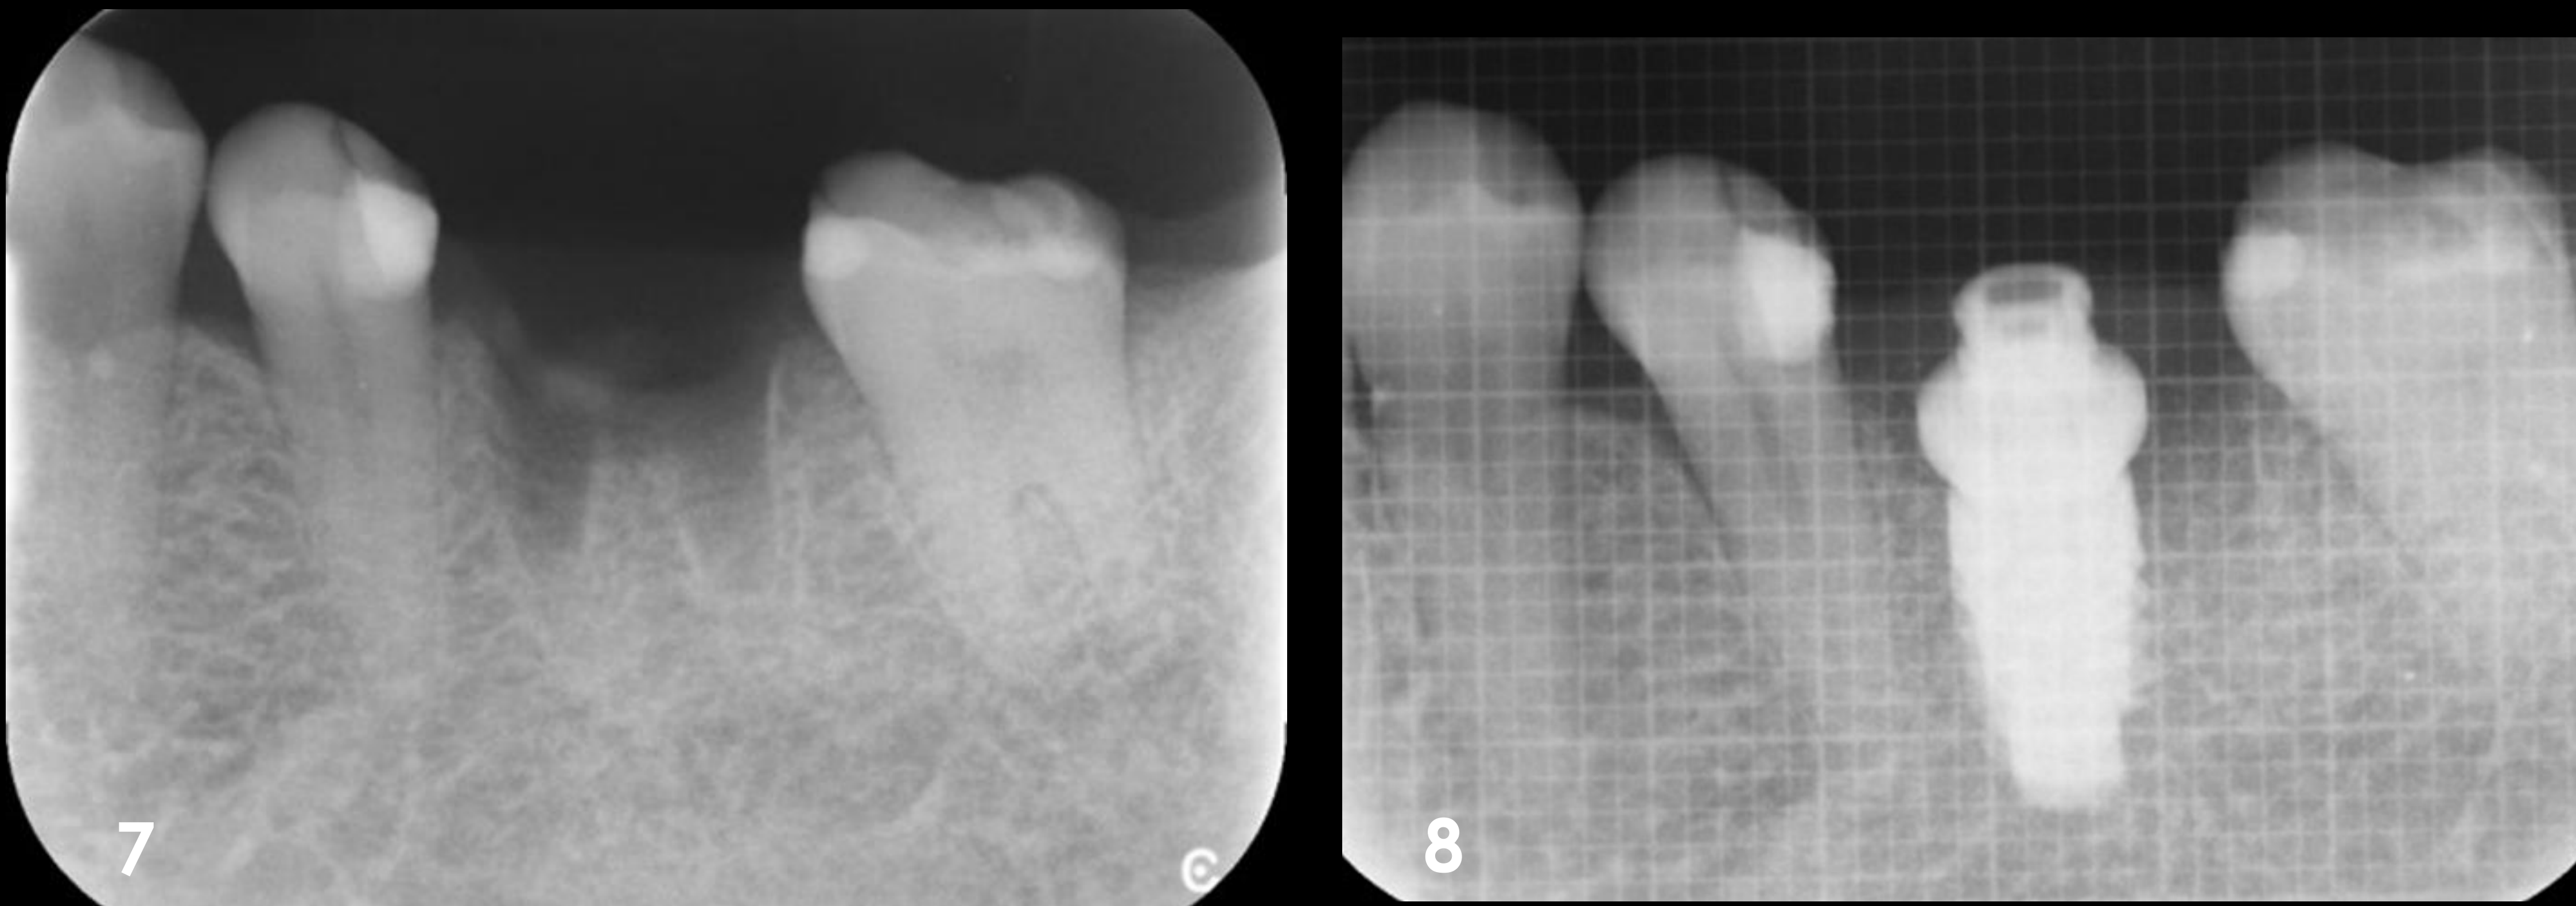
8 Periapical radiograph of extraction socket: the septum bone is preserved and the implant was placed that engaged both the septum and mesial socket.
